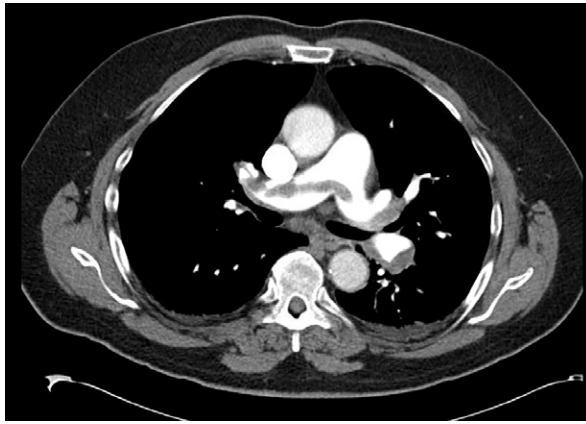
Patient 1. Computed tomographic angiogram shows a pulmonary embolus extending into the right and left pulmonary arteries.
